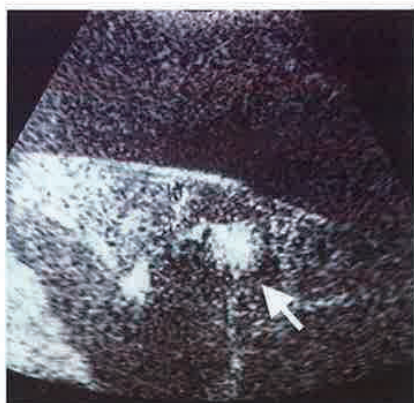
Portal-phase dynamic sonogram obtained 40 seconds after contrast medium injection revealing marked enhancement of the hepatic nodule in segment VI (arrow) on right intercostal scanning. Massive ascites is also demonstrated.
